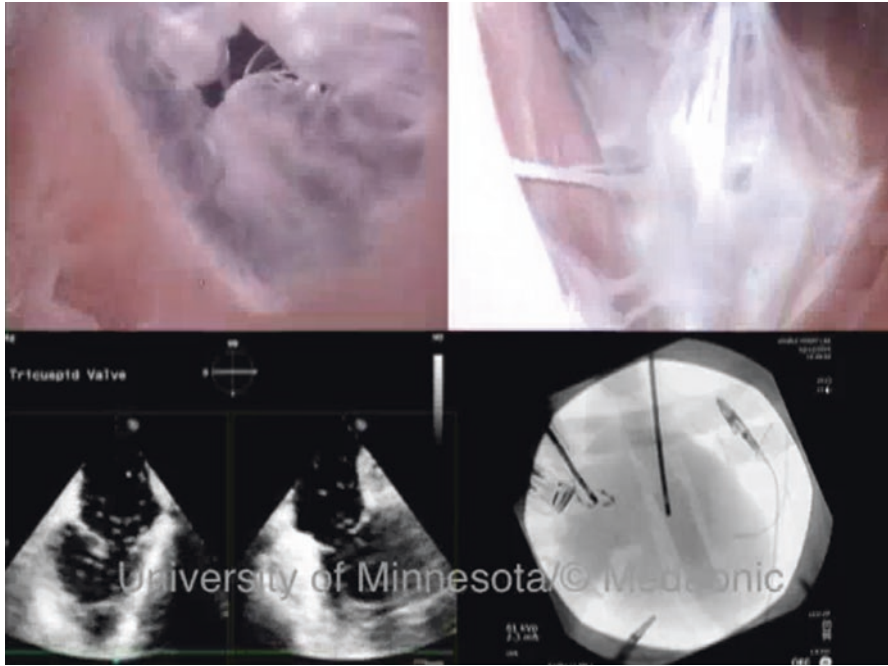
Unique views of the tricuspid valve within a reanimated human heart imaged using the following: (1) an endoscope placed within the right atrium (upper left panel), (2) an endoscope placed within the right ventricle (upper right panel), (3) fluoroscopy with an anterior-posterior orientation (lower left panel), and (4) ultrasound (lower right panel). (Modified from the Atlas of Human Cardiac Anatomy [29])
